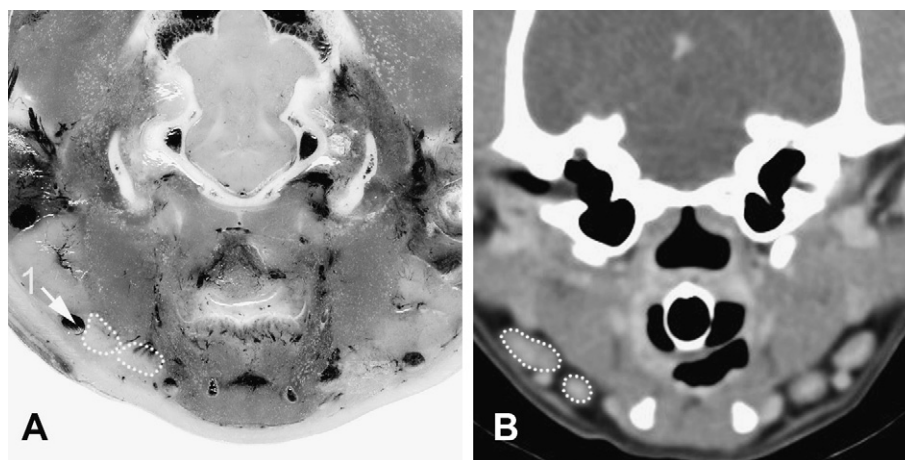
Transverse, plastinated-embedded (A) and post-contrast, CT cross-section (B) displayed in a soft tissue window (WL 90, WW ± 350), at the level of the mandibular lymph nodes (....) (1) facial vein.
